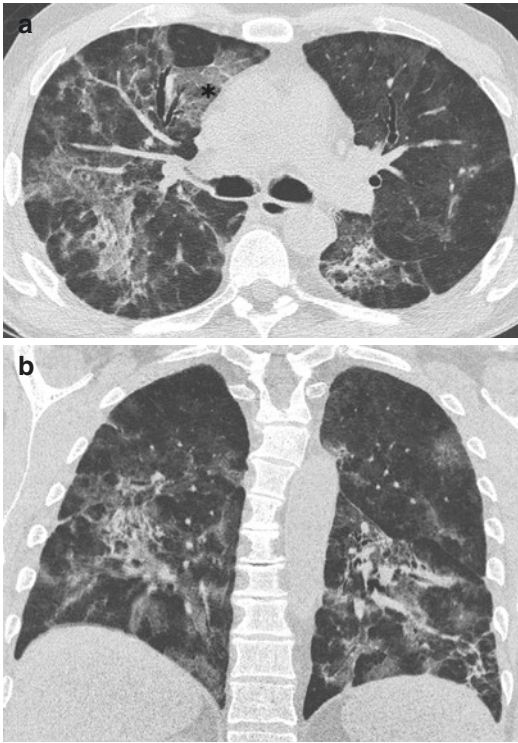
Hairy cell leukemia and COVID-19 pneumonia in a 55-year-old man. (a) Axial and (b) coronal CT scans show bilateral areas of ground-glass opacities in a peribronchovascular distribution
